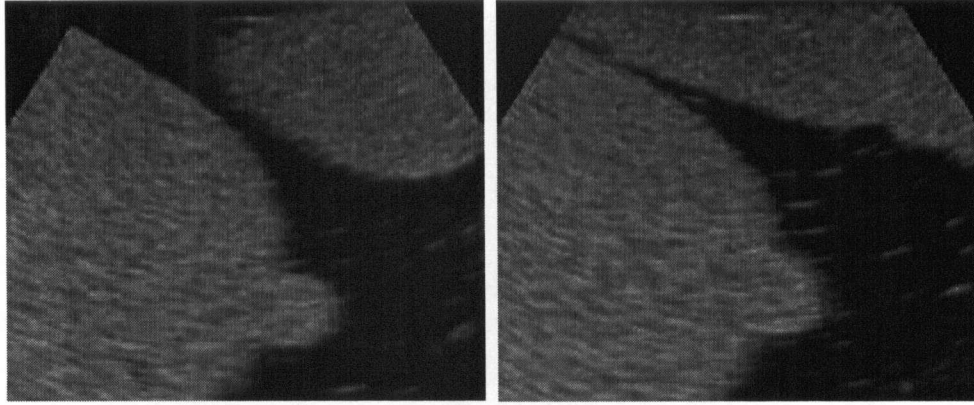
Determining the start time of the probe translation from acquired ultrasound images. The image acquired while the probe was initially stationary is shown in (a). The first image to display a significant change in content from (a) corresponding to the start of probe movement is shown in (b).
